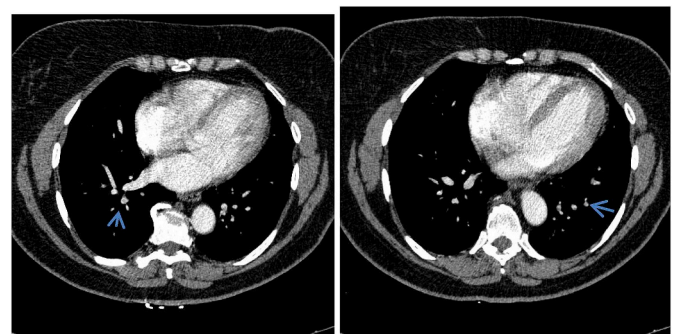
50-year-old woman with two weeks of all-day continuing cough. CT pulmonary angiography shows pulmonary emboli in bilateral lower lobe artery (arrows).
